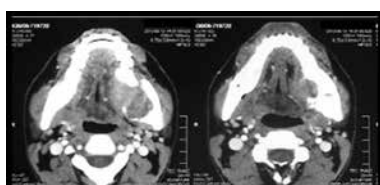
CT scan showing soft tissue mass in lower left jaw causing resorption of the lingual cortical plate.
